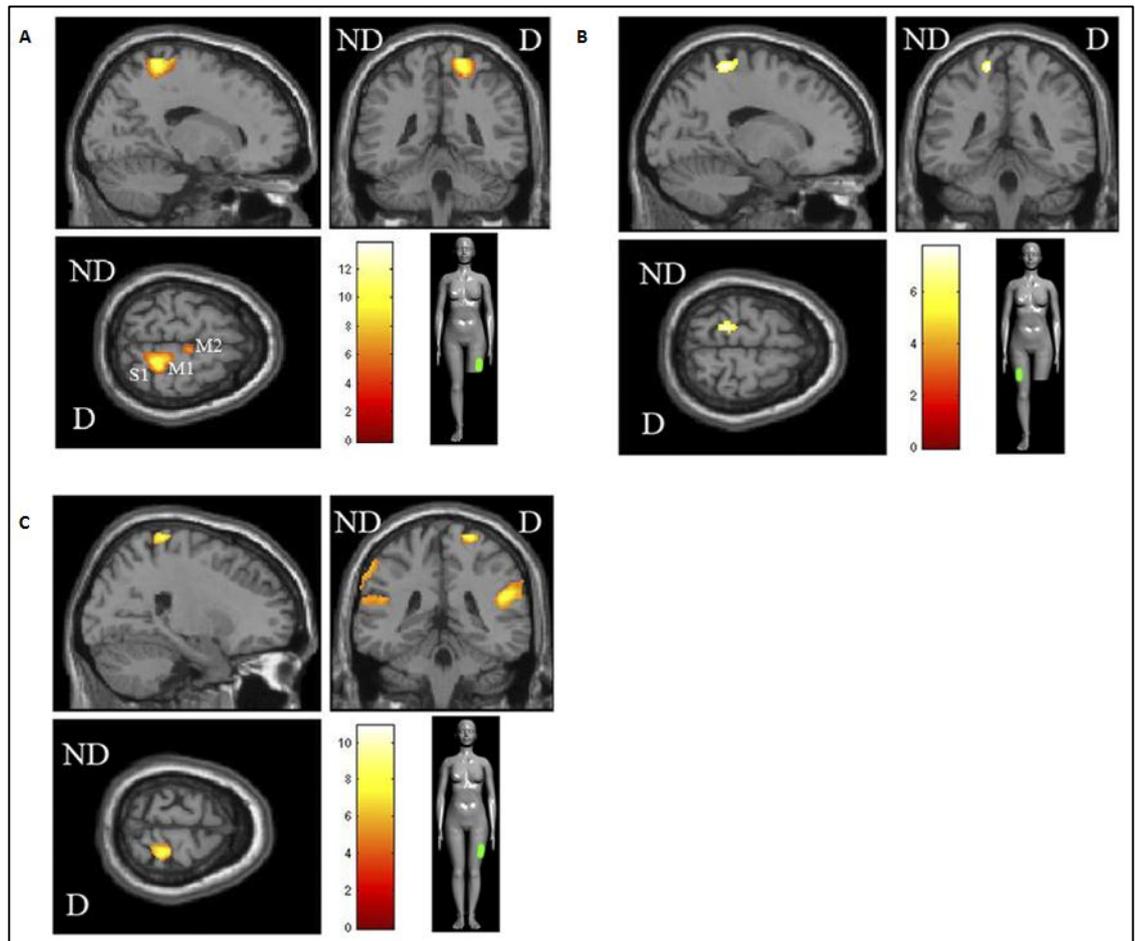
Functional MRI activation maps during tactile stimulation.
